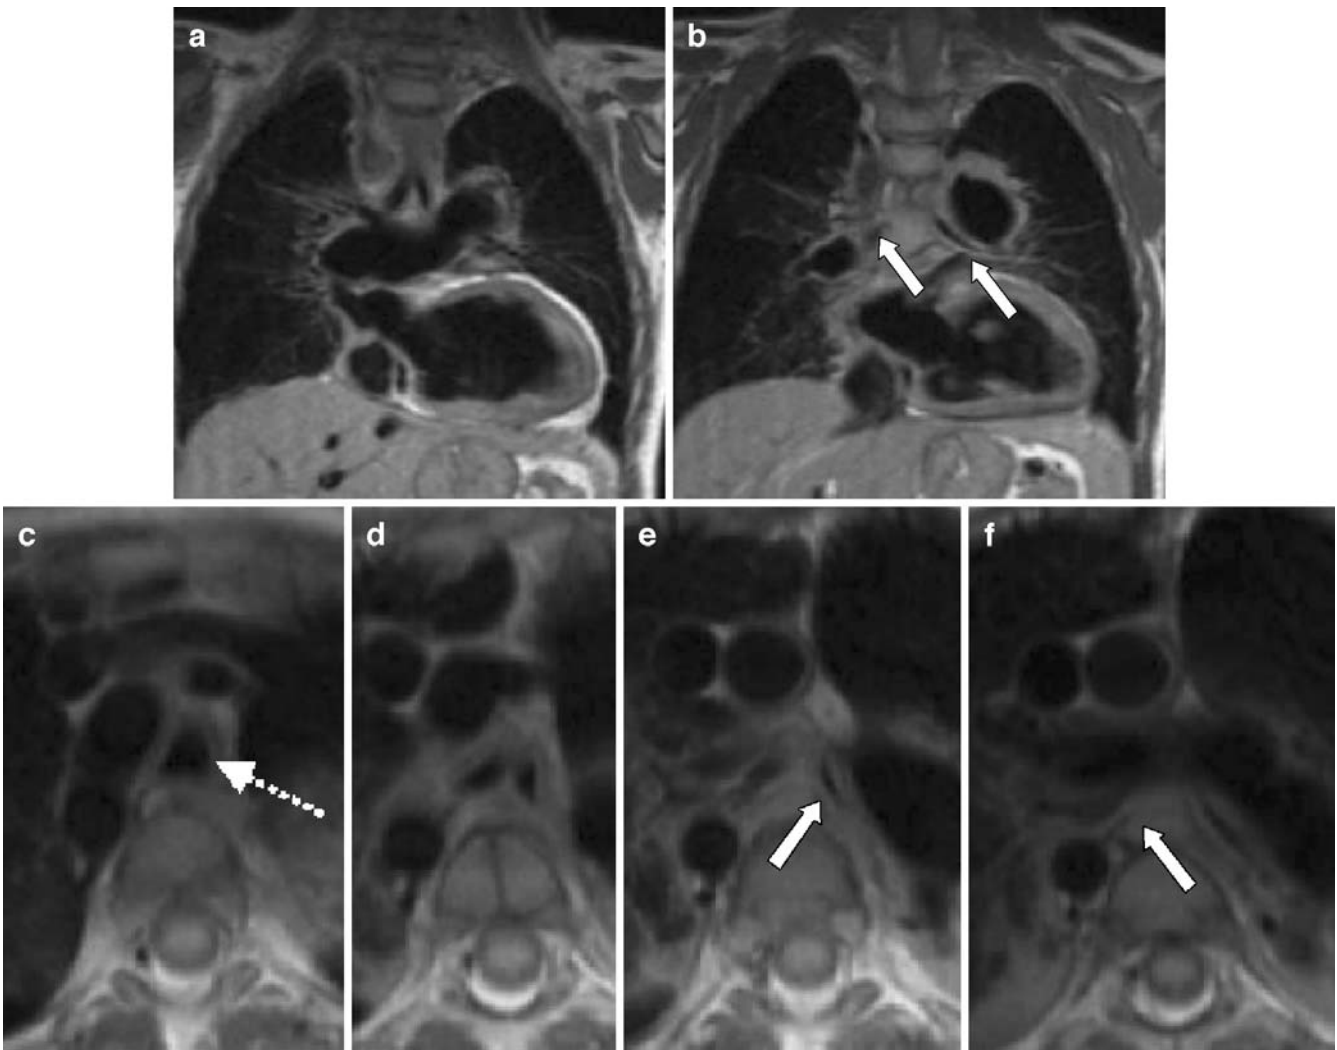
Selected coronal (a, b) and sequential axial (c, d, e, f) MR images show the normal-caliber trachea (*dashed arrow*) and carina with marked narrowing of the right and left mainstem bronchi (*solid white arrows*). Additionally, the absence of a normal thymus is noted. Incidentally noted are a right-side aortic arch and a butterfly vertebral body
